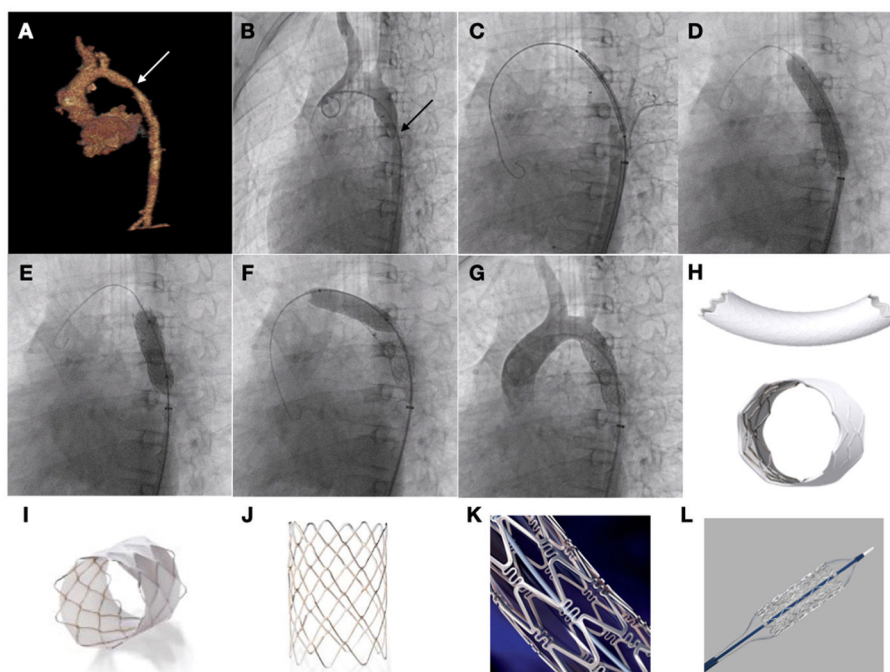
Patient aged 10 years with Williams syndrome and recurrent coarctation of aorta referred for percutaneous stent implantation. (A and B) CT and angiography images showing narrowing of the aortic lumen. (C) Advancing the stent to the target area. (D) Inflation of stent with visualization of reduced expansion at the level of the isthmus. (E and F) Post-dilation of both the distal and the proximal portions of the stent. (G) Angiographic verification. (H) BeGraft stent. (I) Covered CP stent. (J) CP stent (uncovered). (K) Palmaz Genesis stent. (L) Formula stent.
